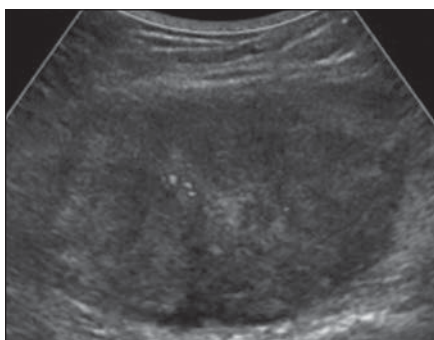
63-year-old man with liposarcoma of thigh. Power Doppler sonographic image of thigh shows heterogeneous solid mass with internal flow, which suggests malignancy. Excision revealed liposarcoma.
